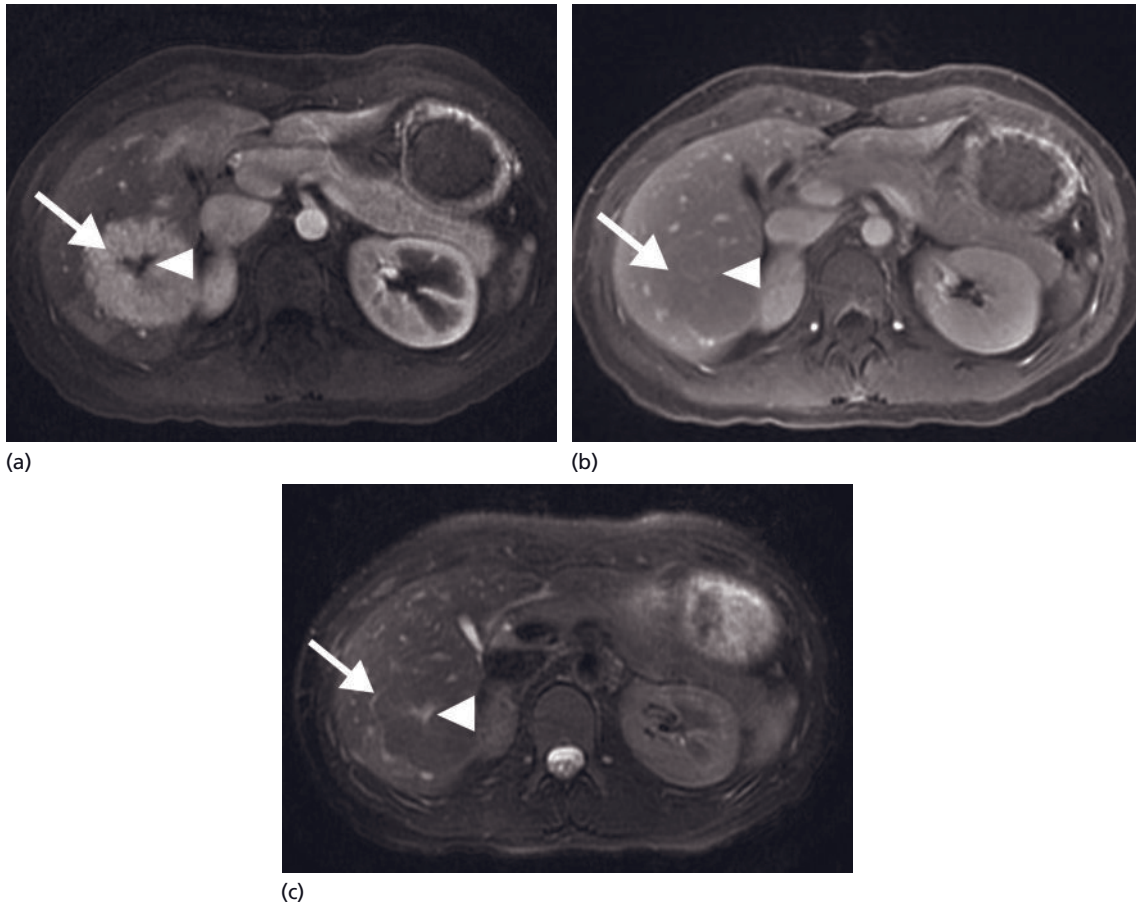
Focal nodular hyperplasia (FNH). (a) Axial, arterial phase MR image demonstrates a hypervascular right hepatic lobe mass (arrow) with hypoenhancing central scar (arrowhead). (b) Portal-venous phase MR image shows that the FNH becomes isointense to liver (arrow), but there is delayed enhancement of the central scar (arrowhead). (c) Axial T2-weighted sequence shows that the FNH (arrow) is similar in intensity to the adjacent liver, except for a hyperintense scar (arrowhead).
